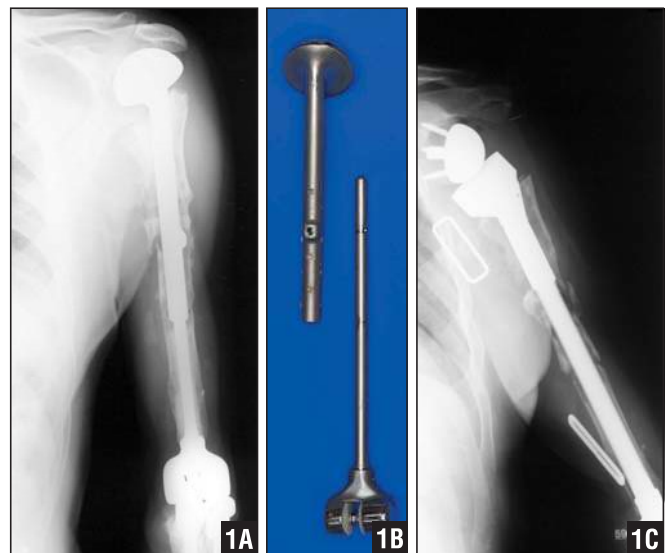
Loose, cranially decentered total humerus replacement in a patient with rheumatoid arthritis (A). Retrieved prosthesis (B). Postoperative radiograph: Custom-made total humerus replacement (W. Link) with inverse shoulder component (DePuy) (C).
